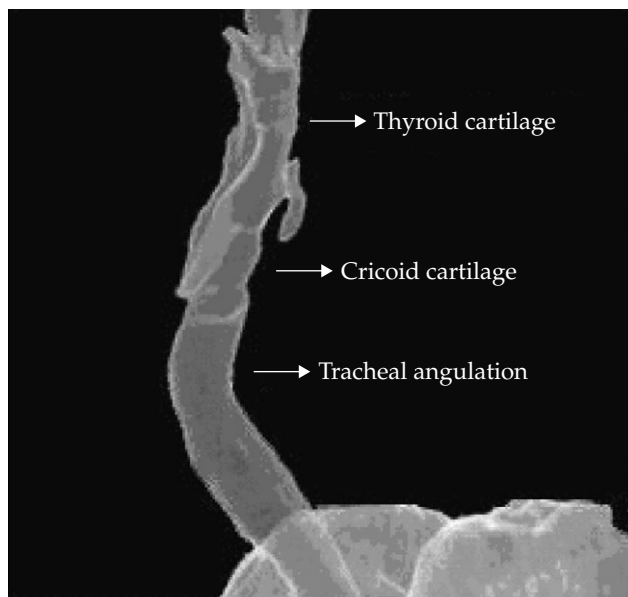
Preoperative computed tomography image of the upper airway shows that the upper trachea is angulated.
